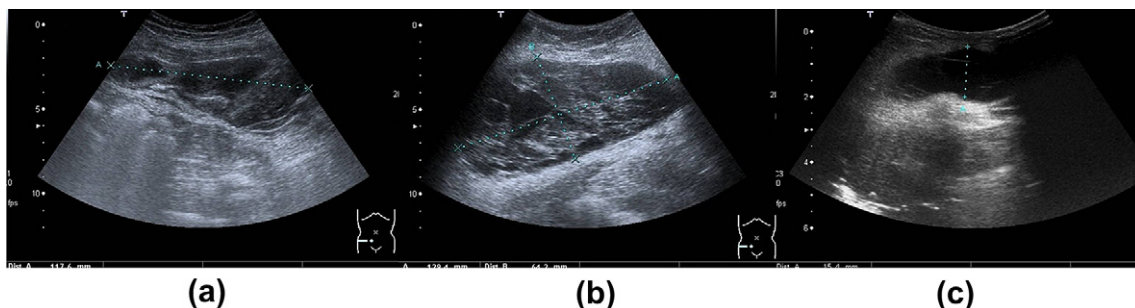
Ultrasound images showing large rectus sheath haematoma. There is mixed echogenicity in (a) in keeping with acute nature. Note the septae within the haematoma in (b) suggesting an organizing haematoma. The lesion in (c) is almost anechoic suggesting liquefaction.
